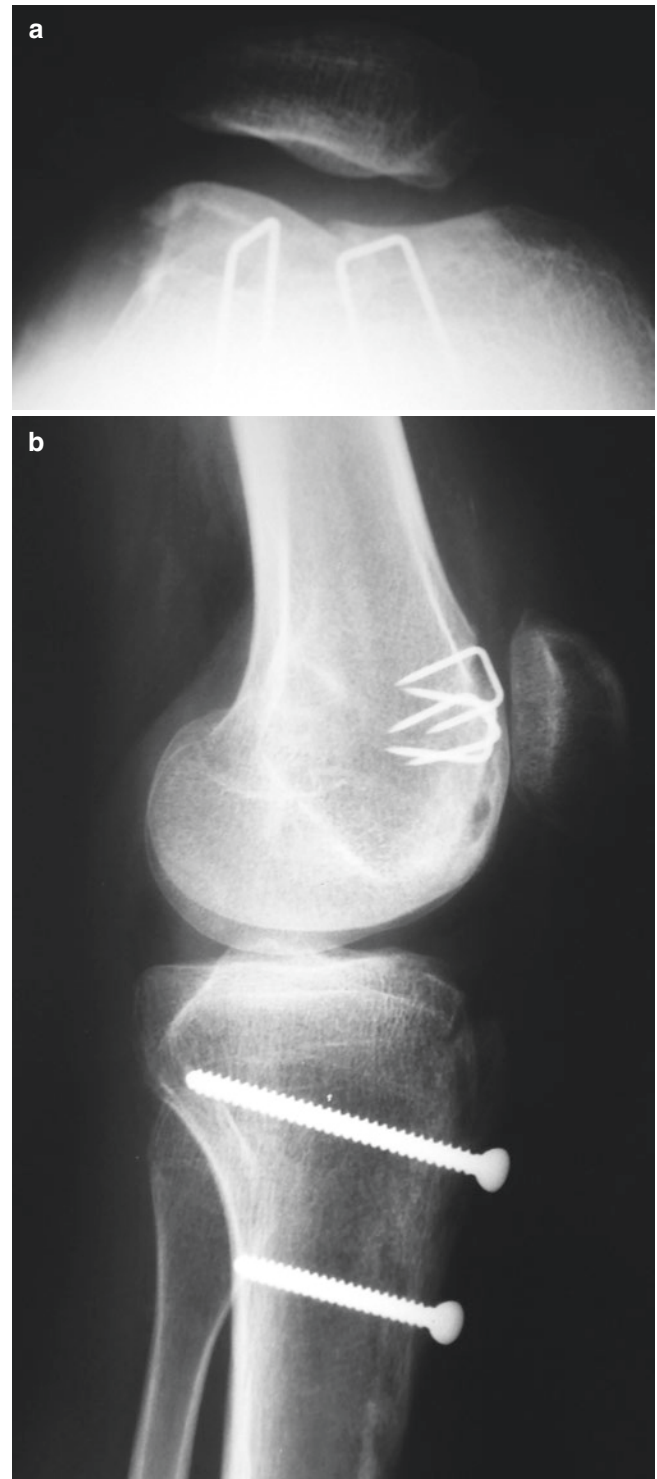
(a, b) Post-operative X-ray
